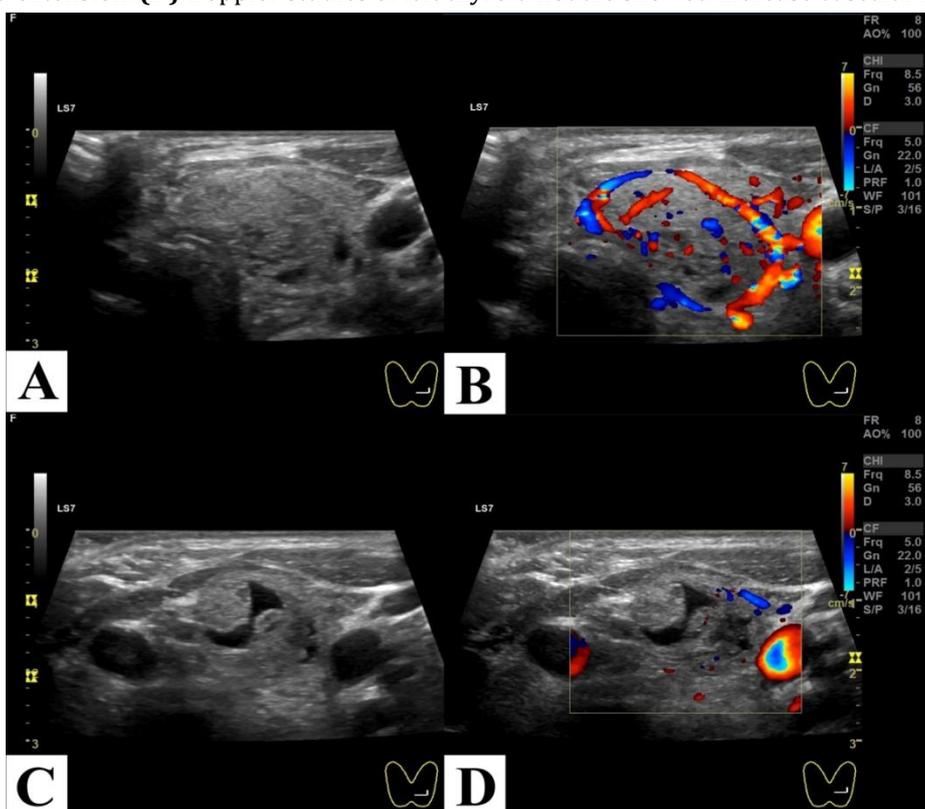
Ultrasound of thyroid gland (Follow up at 20th weeks)
